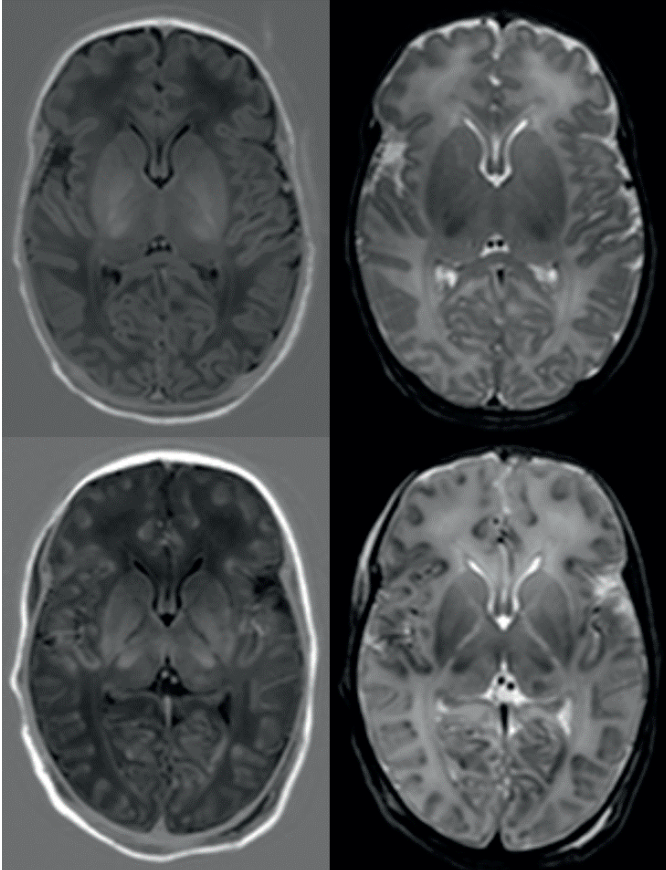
MRI of two neonates with HIE. The two images on top are T1 (left) and T2 (right) weighted images with normal findings. The two images below are T1 (left) and T2 (right) weighted images with total brain injury pattern involving both basal ganglia and thalami, posterior limb of the internal capsule, white matter, and cortex. Images obtained in the THIN study.
